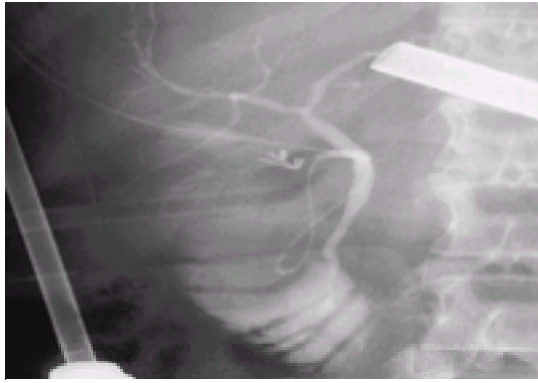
A normal laparoscopic peroperative cholangiogram. The cystic duct is cannulated in the normal way and the cannula held in place either with a special instrument or with a removable metal clip. The laparoscopic ports are not radio-opaque and must be held out of the way whilst the radiographs are taken.
